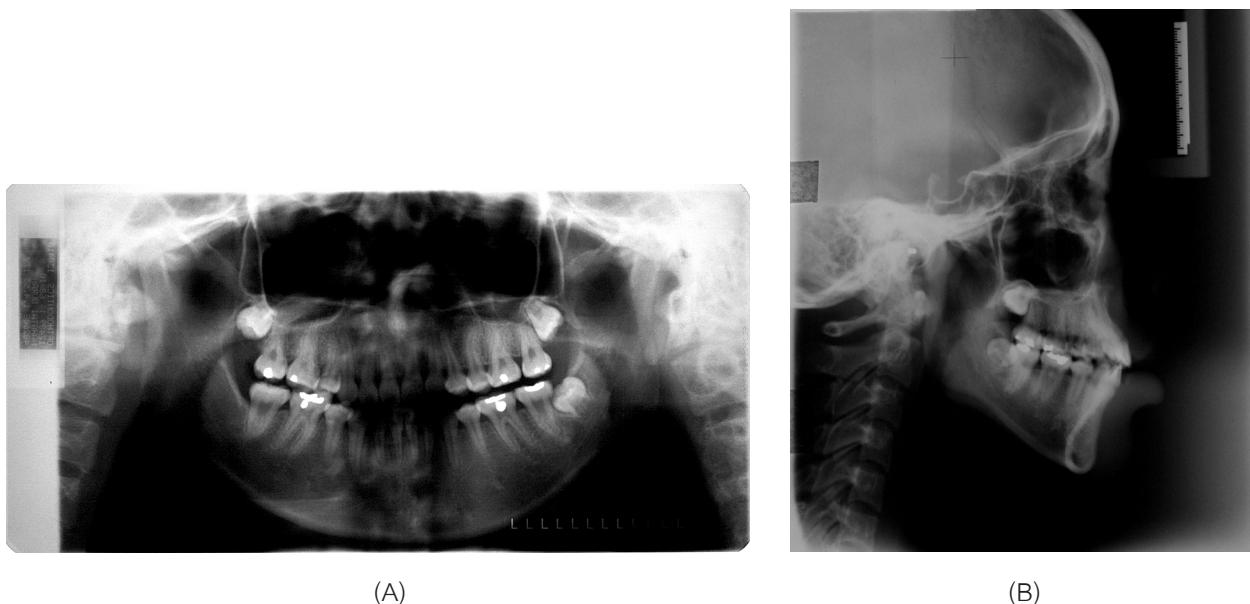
Panoramic radiograms (A) and lateral cephalograms (B) at posttreatment
